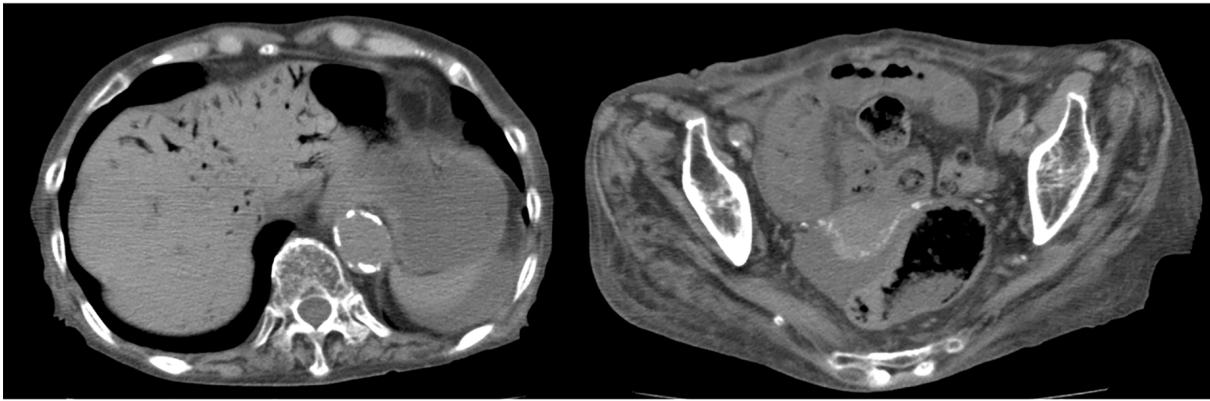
Abdominal computed tomography images of case 3 on admission. Left lobe hepatic portal venous gas and the moderate amount of ascites are seen.
